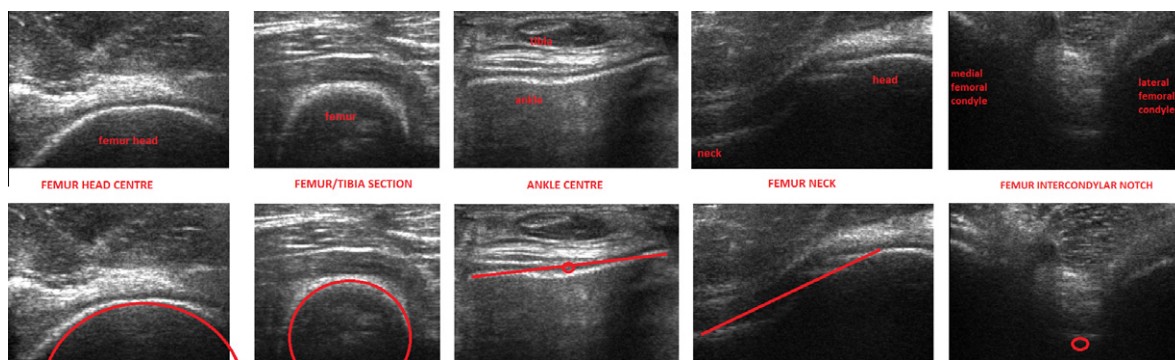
The real ultrasonic scans of human limb (femur head, femur/tibia shaft section, ankle, femur neck and femur condyles).
